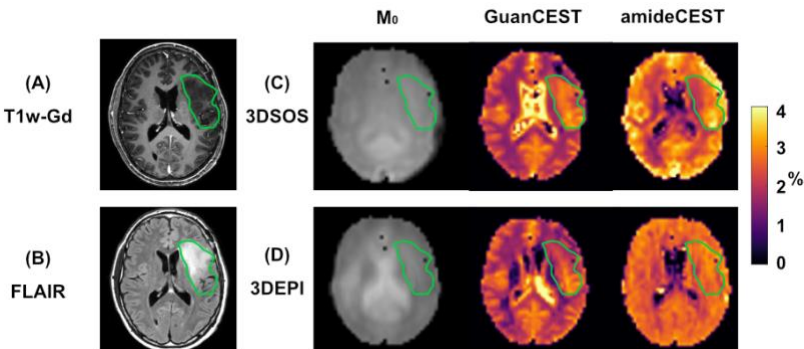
Demo of a glioma patient. Tumor circled in green defined by (A) T1-weighted image after the injection of gadolinium and (B) FLAIR. M_0 image, GuanCEST, and amideCEST mappings by (C) 3DSOS and (D) 3DEPI.
